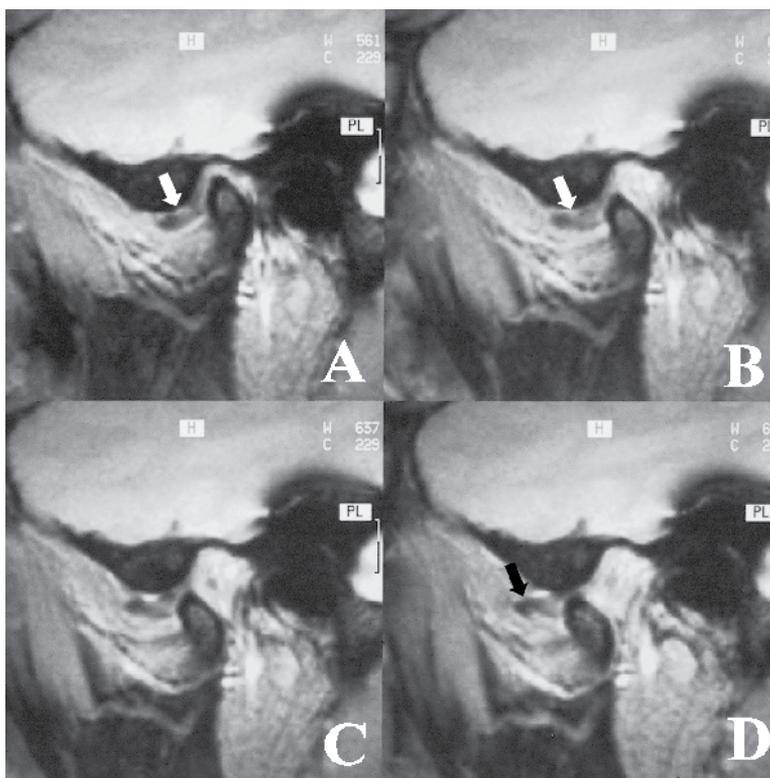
MRI of TMJ disc displacement without reduction
